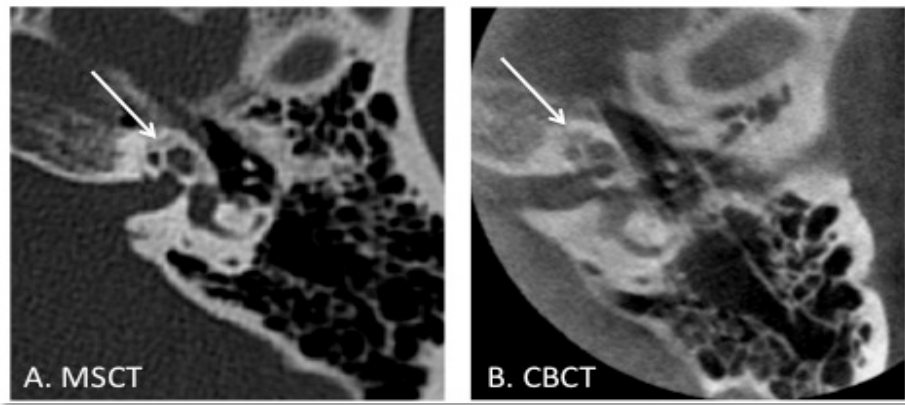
Axial view, otosclerotic cochlear demineralization in the same subject using MSCT (A) and CBCT (B).
